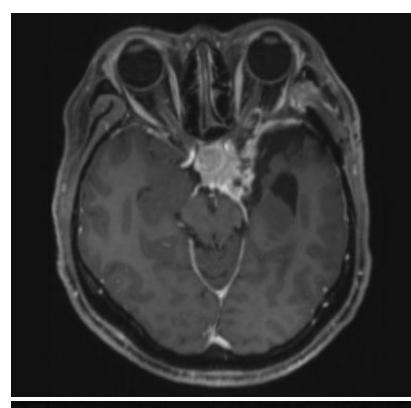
October 2022 – Postop MRI s/p retrosigmoid craniotomy
